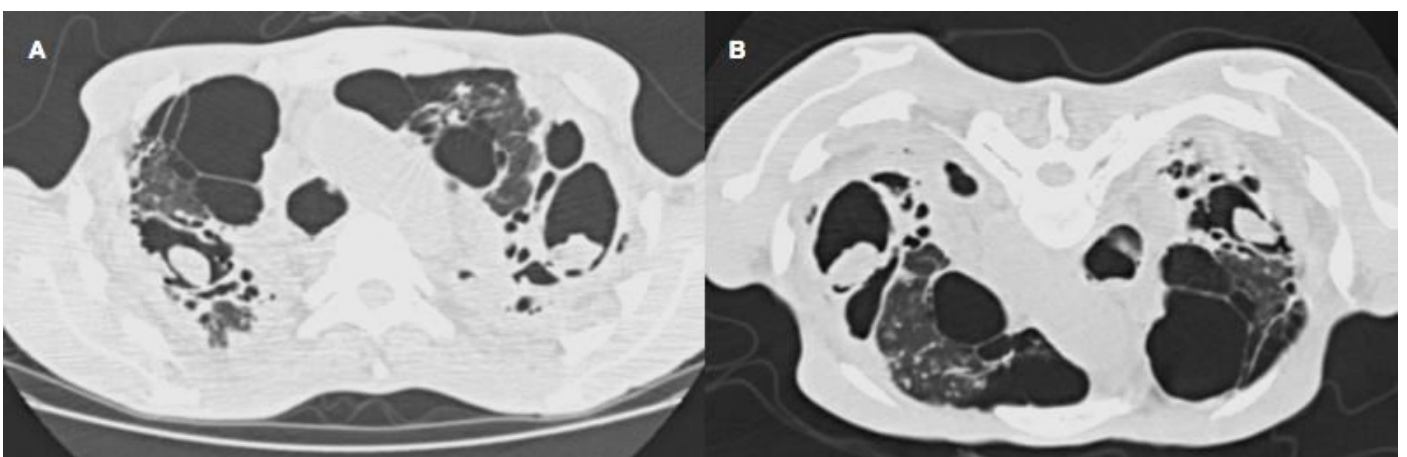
A 78-year-old man diagnosed with chronic pulmonary aspergillosis (chronic cavitary form). The patient had previous history of smoking and mycobacterial infection, and presented with chronic cough (9 months) and recent episodes of hemoptysis. Axial computed tomography scans of the lungs in supine (A) and prone (B) reveal extensive architectural distortion in the upper lobes, with bullae and pulmonary cavities containing rounded soft-tissue material (fungus ball).
